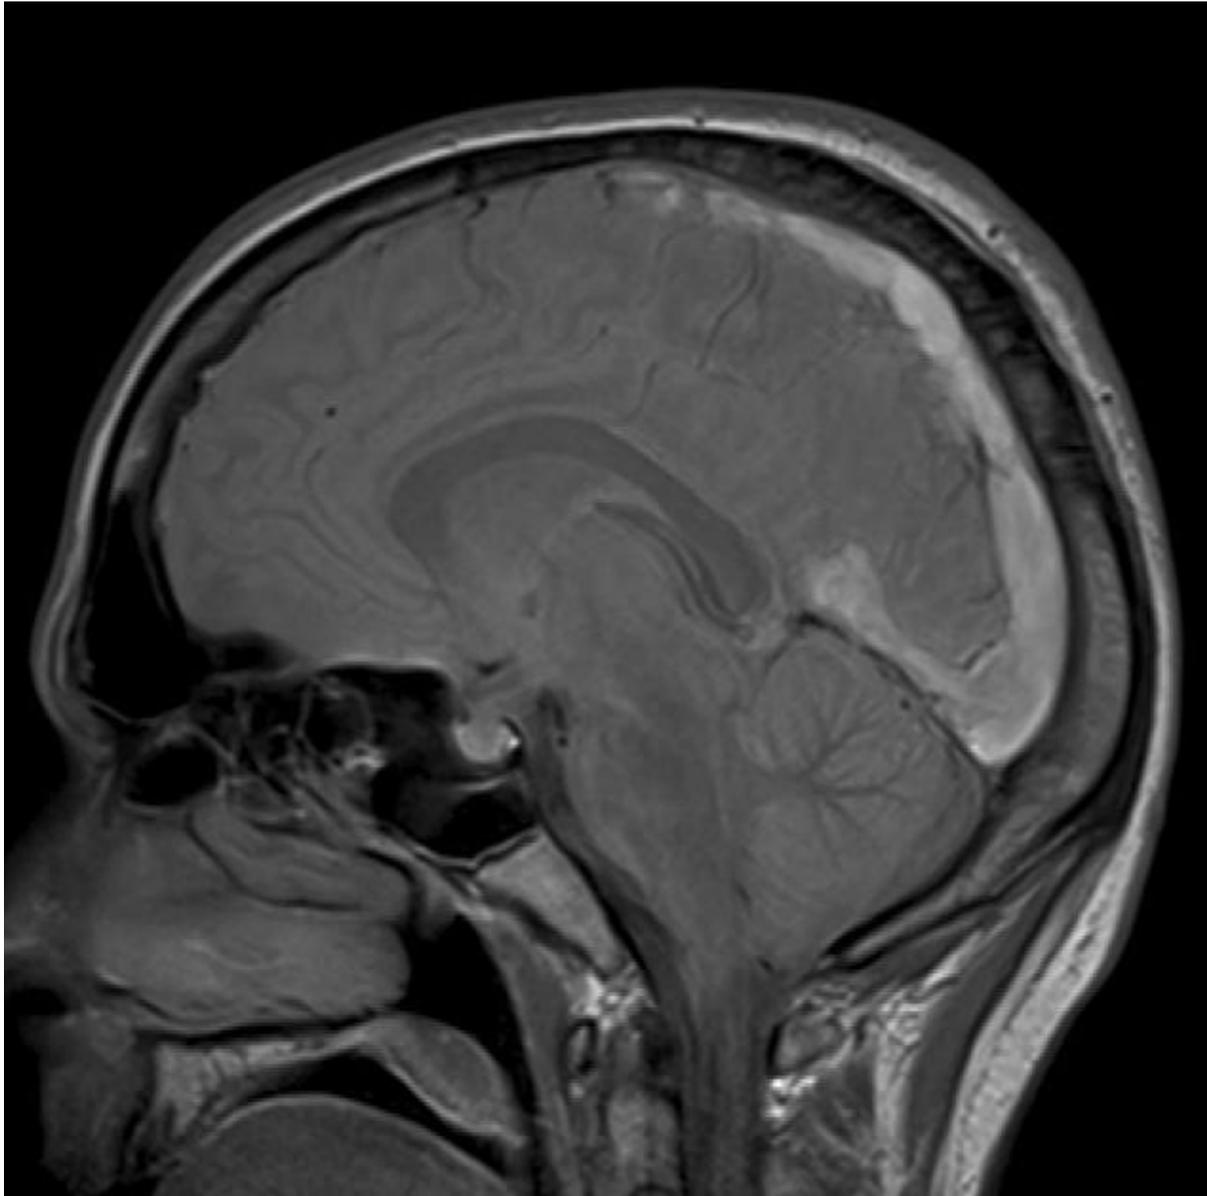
MRI of the brain showing signal hyperintensity of superior longitudinal sinus, straight sinus, and transverse sinus.
